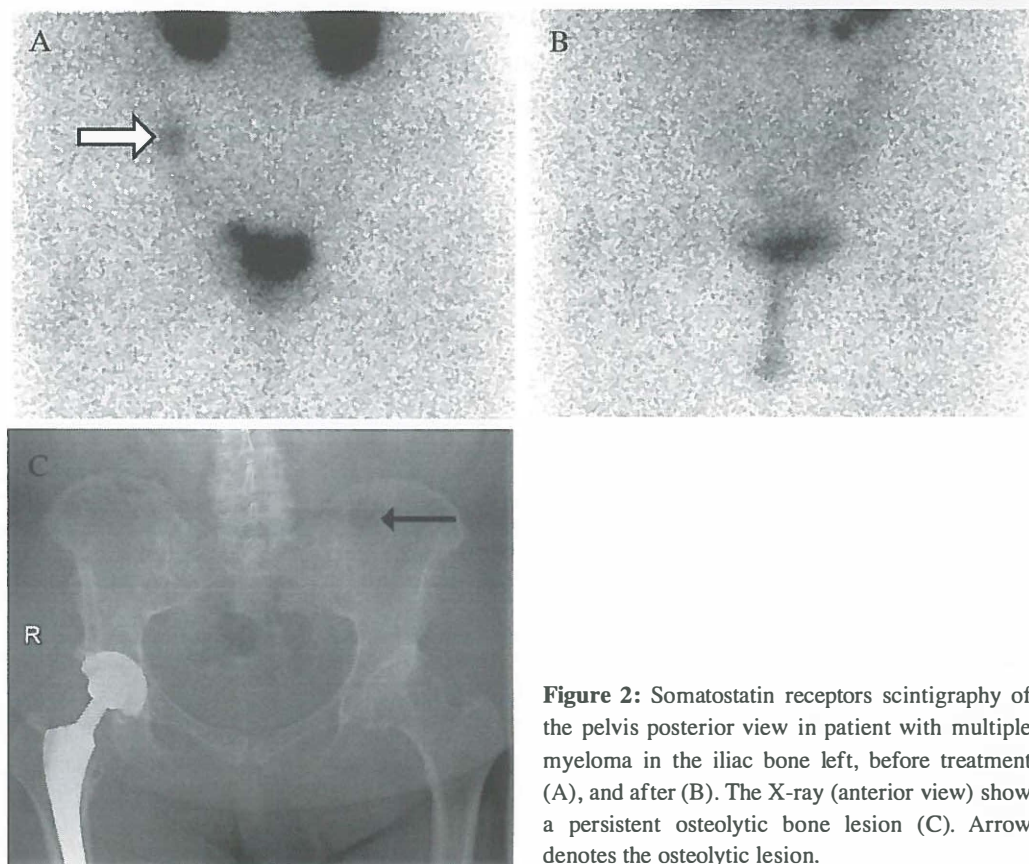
Somatostatin receptors scintigraphy of the pelvis posterior view in patient with multiple myeloma in the iliac bone left, before treatment (A), and after (B). The X-ray (anterior view) show a persistent osteolytic bone lesion (C). Arrow denotes the osteolytic lesion.
